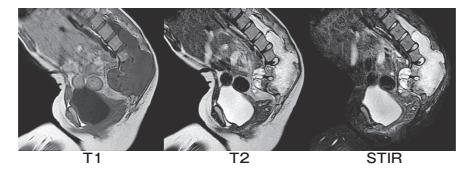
MRI showed a large sacral tumor with well-defined margins. The tumor's signal intensity on MRI was equal to that of the abdominal muscles on T1-weighted images but was higher on T2-weighted images. The signal intensity of the tumor was not suppressed on STIR images. From the MRI images, the tumor appeared to originate from the right S2 nerve root.
